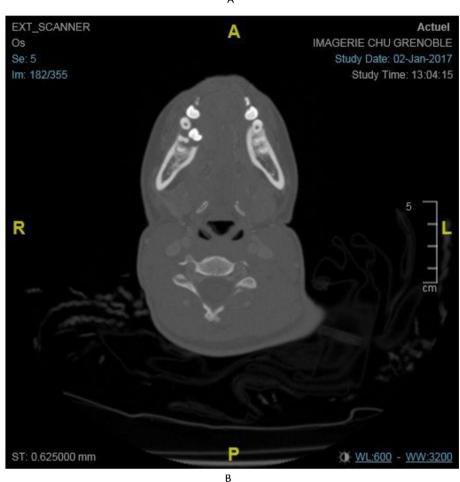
A) Included supernumerary tooth on a dental CT scan. B) Lysis of the lingual cortex of the right posterior mandible on a transverse CT scan.
